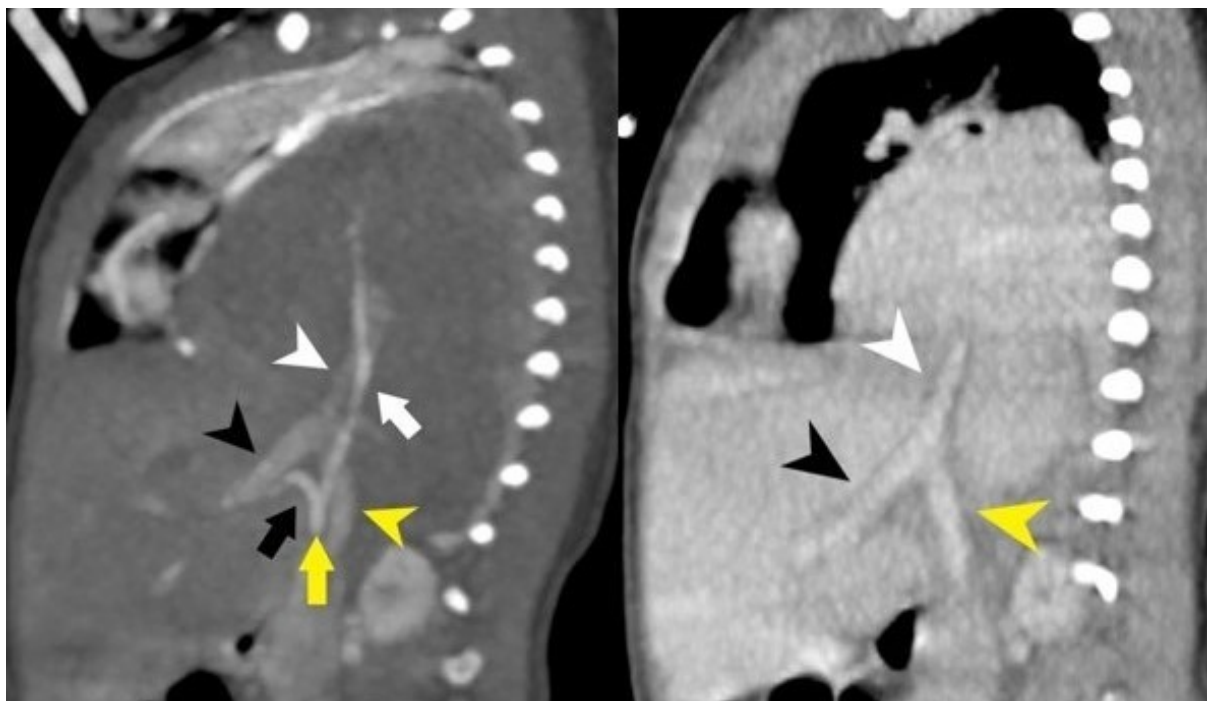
Sagittal reformatted image of CT thorax compare the differentiation of vascular structures in the arterial phase (A) which was performed at our centre and venous phase (B) which was initially performed at primary hospital. The common hepatic artery (yellow arrow) gives rise to branches which supply the liver (black arrow) and the intrathoracic mass (white arrow). The main portal vein (yellow arrowhead) also has branches to the liver (black arrowhead) and to the intrathoracic mass (white arrowhead). (Click on image to enlarge)
